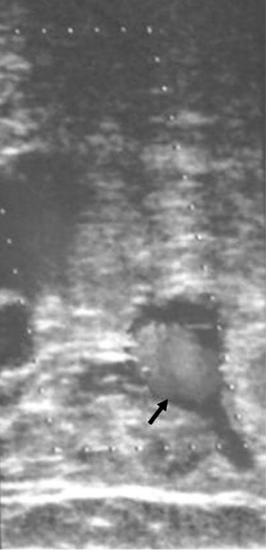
Thrombosis in the femoral vein by Doppler USG
